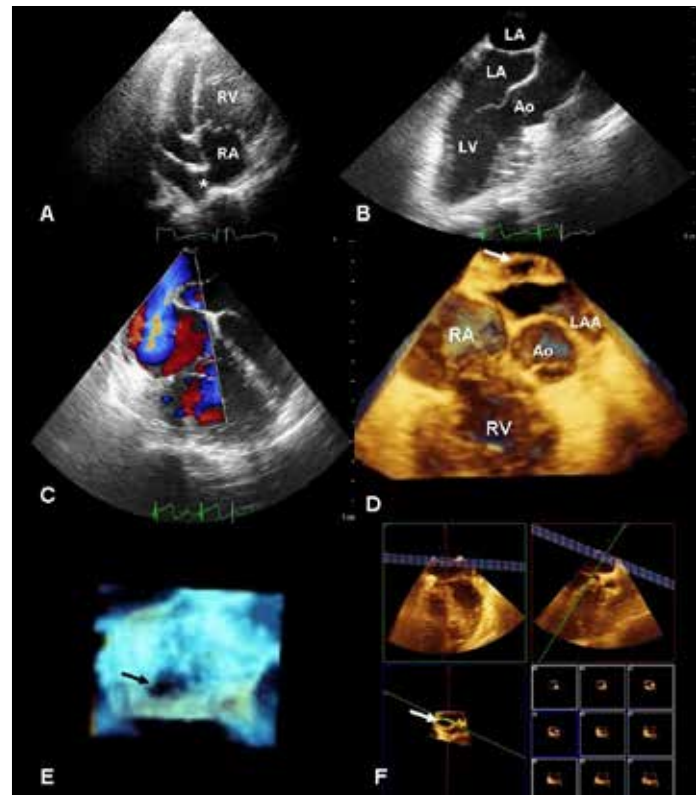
Two-dimensional transthoracic echocardiography revealed dilated right atrium and ventricle, atrial septal defect (ASD) and a membrane at the left atrium (A). Two-dimensional transesophageal echocardiography confirmed cor triatriatum sinister and ASD (B, C). Three-dimensional transesophageal echocardiography revealed a single opening on the fibromuscular membrane (D, E). The area of orifice using iSlice multi-planar review mode was 1.64 cm² (F)
